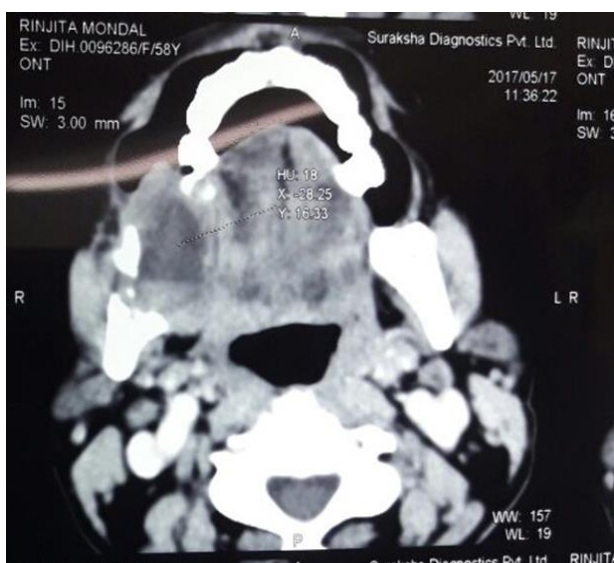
CT scan showing buccolingual expansion of cortical plates of mandible.
